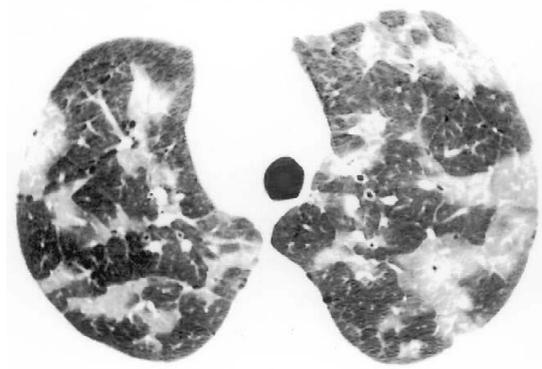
HRCT showing typical ground glass opacity (Adapted from reference 6)
